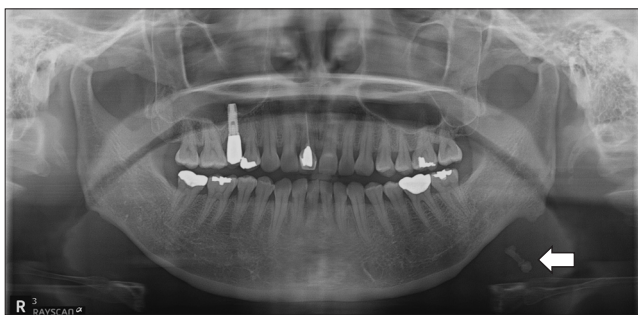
Panoramic radiograph showed radiopaque lesions on left submandibular area (arrow).
